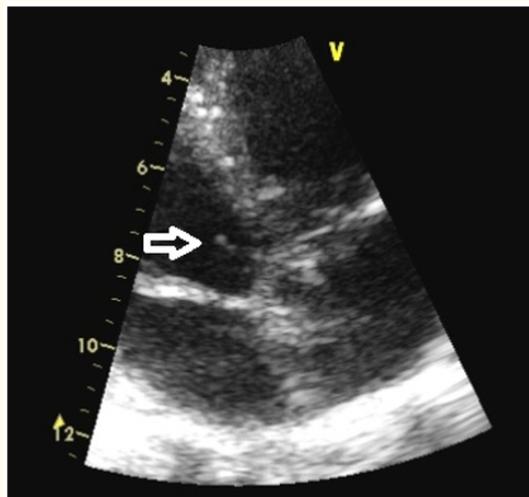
Transthoracic echocardiogram showing the small Lambl's excrescence.
